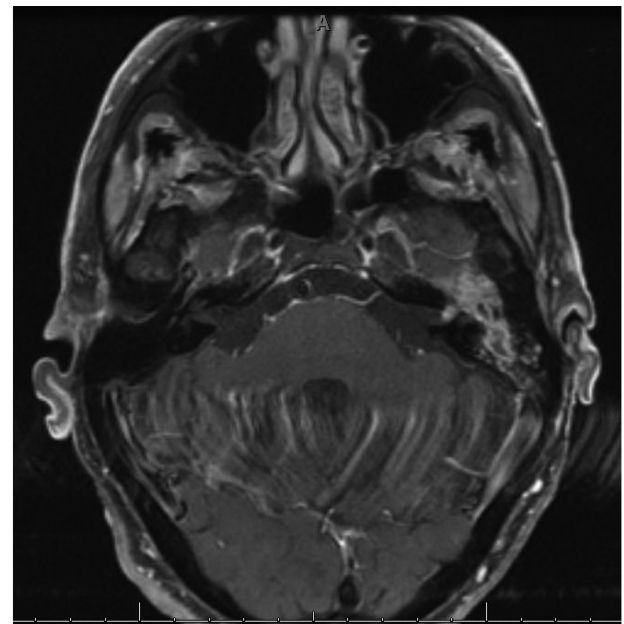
Axial T1 MRI postcontrast and fat saturated demonstrating enhancing tumor, squamous cell carcinoma, in the left mastoid tracking along the tympanic segment of the facial nerve, through the geniculate ganglion, and extending into the proximal IAC. This was resected through a translabyrinthine approach.
